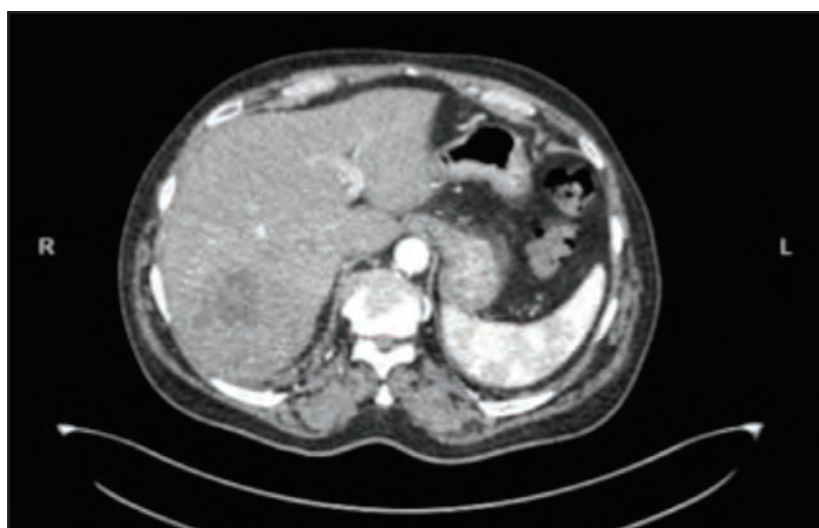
Multiloculated rim enhancing hypodense lesion with central fluid density seen in four phase liver computed tomography.
